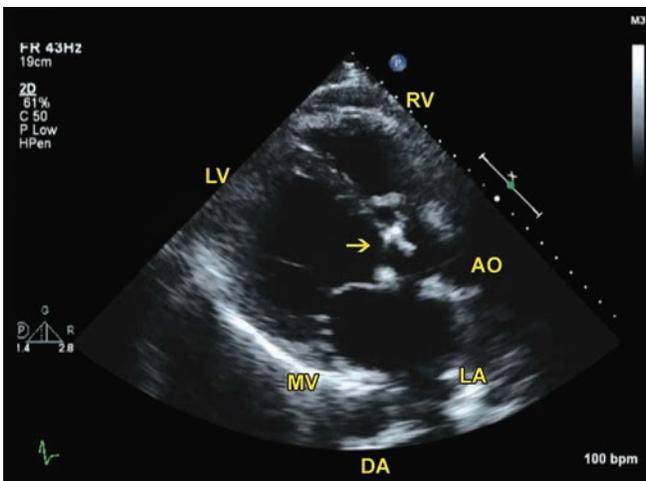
TTE parasternal long axis view demonstrates rocking motion of the aortic bioprosthesis; this indicates significant dehiscence of the aortic bioprosthesis (arrow) and severe paravalvular AR. Note that the bioprosthesis leaflets are thickened and restricted.
